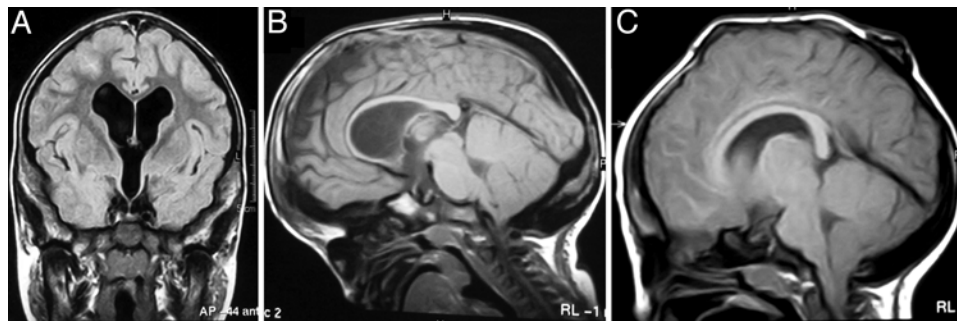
Magnetic resonance images from the 2 cases. A: Axial image showing ventriculomegaly in the absence of periventricular lucencies in Case 1. B: Sagittal image demonstrating no Chiari malformation in Case 1. C: Sagittal image in Case 2 showing the skull with digitiform projections and the superior sagittal sinus protruding through the sagittal suture, as well as a Chiari malformation.
